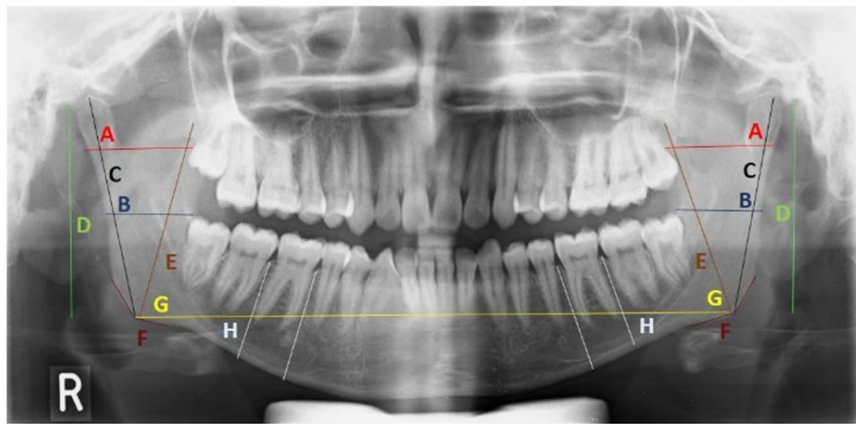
X-Ray image teeth
